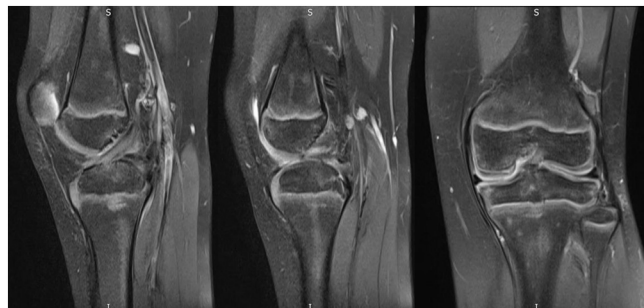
Pre-operative MRI images demonstrating PCL rupture and intact ACL.
